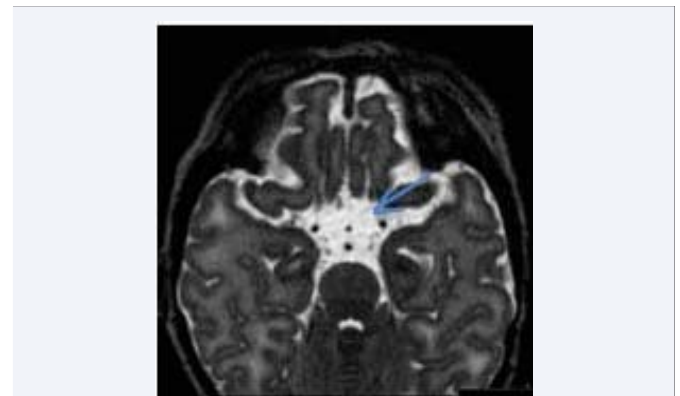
Case 3- MRI brain showing absent optic chiasma.
